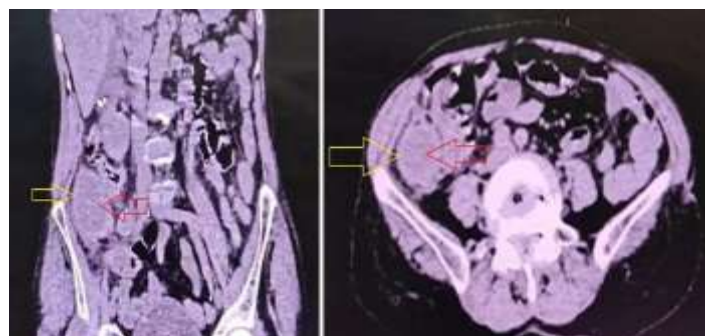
Computed tomography image showing yellow arrow: Cystic dilatation of the Appendix consistent with appendiceal mucinous neoplasm; Red arrow: Intraluminal mucin within the dilated appendix
